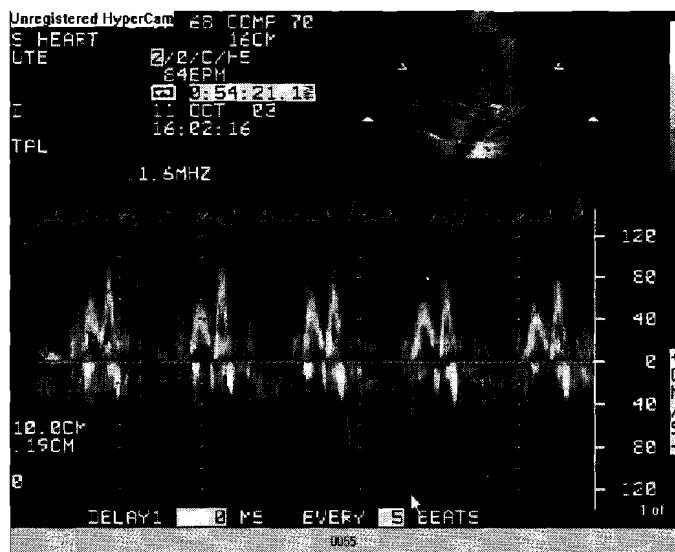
(a): Apical four chamber view showing pulse wave Doppler trace across mitral valve, since blood flow is from LA to LV i.e. towards transducer therefore shows positive trace.
